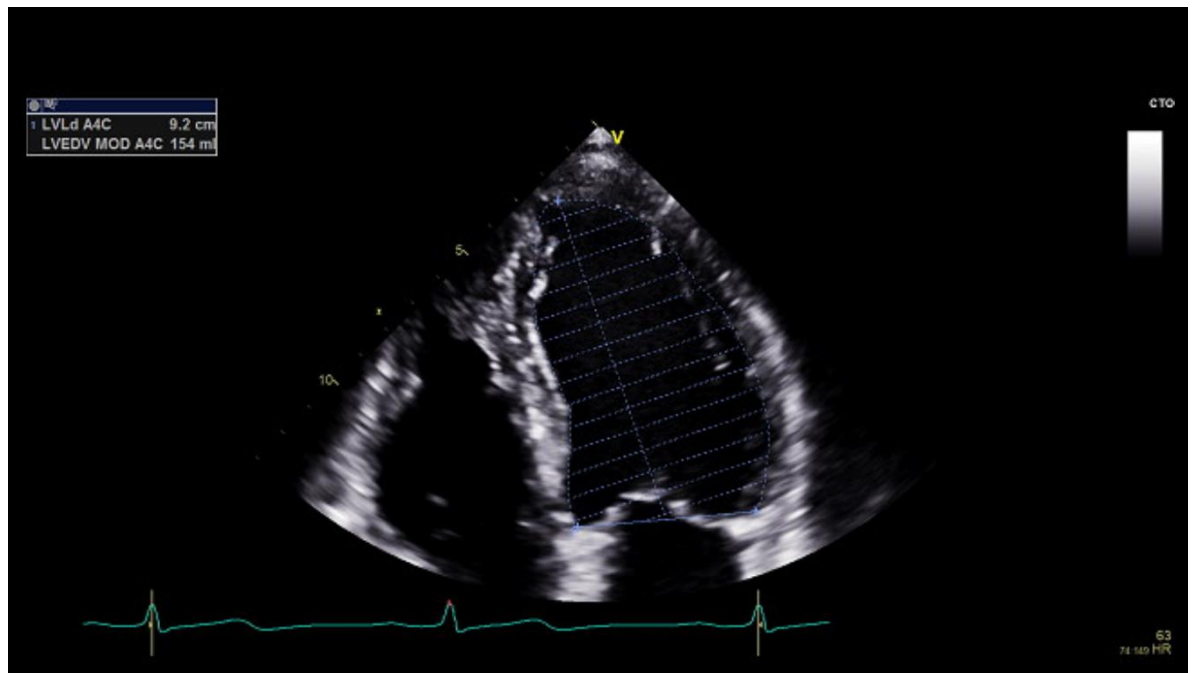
left ventricle end-diastolic volume obtained by tracing the left ventricle endocardial border at the end diastole in apical four-chamber view.
